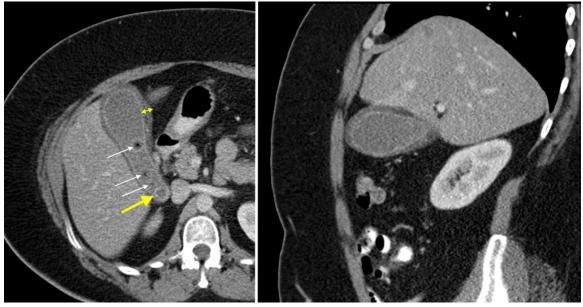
CT scan of abdomen. Acute calculous cholecystitis. Thickened, edematous gallbladder wall (indicated by the double-headed arrow). There are multiple gallbladder calculi (white arrows), one of which looks like it's stuck in the gallbladder neck (large yellow arrow). The gallbladder wall is also well seen on the sagittal image on the right.
